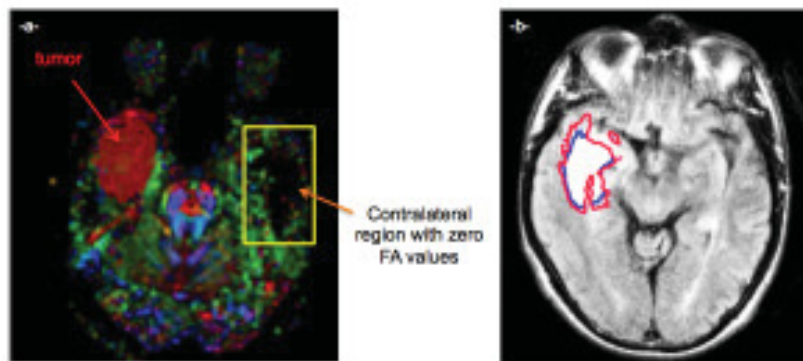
Data encountered problems (Patient D): large black holes in the DTI.* (a) Tumor segmentation in red is overlaid on the fractional anisotropy map, a measure derived from Diffusion Tensor Imaging. The significantly missing diffusion signal in the contralateral region to tumor segmented tissue prohibited our proceeding to the symmetrization process and therefore we used for our estimation the affected tissue tensors by tumor infiltration. (b) The tumor boundary is drawn on the FLAIR image at the first and second time points in light and dark blue (in this slice they are identical) and at the third time point in red.
